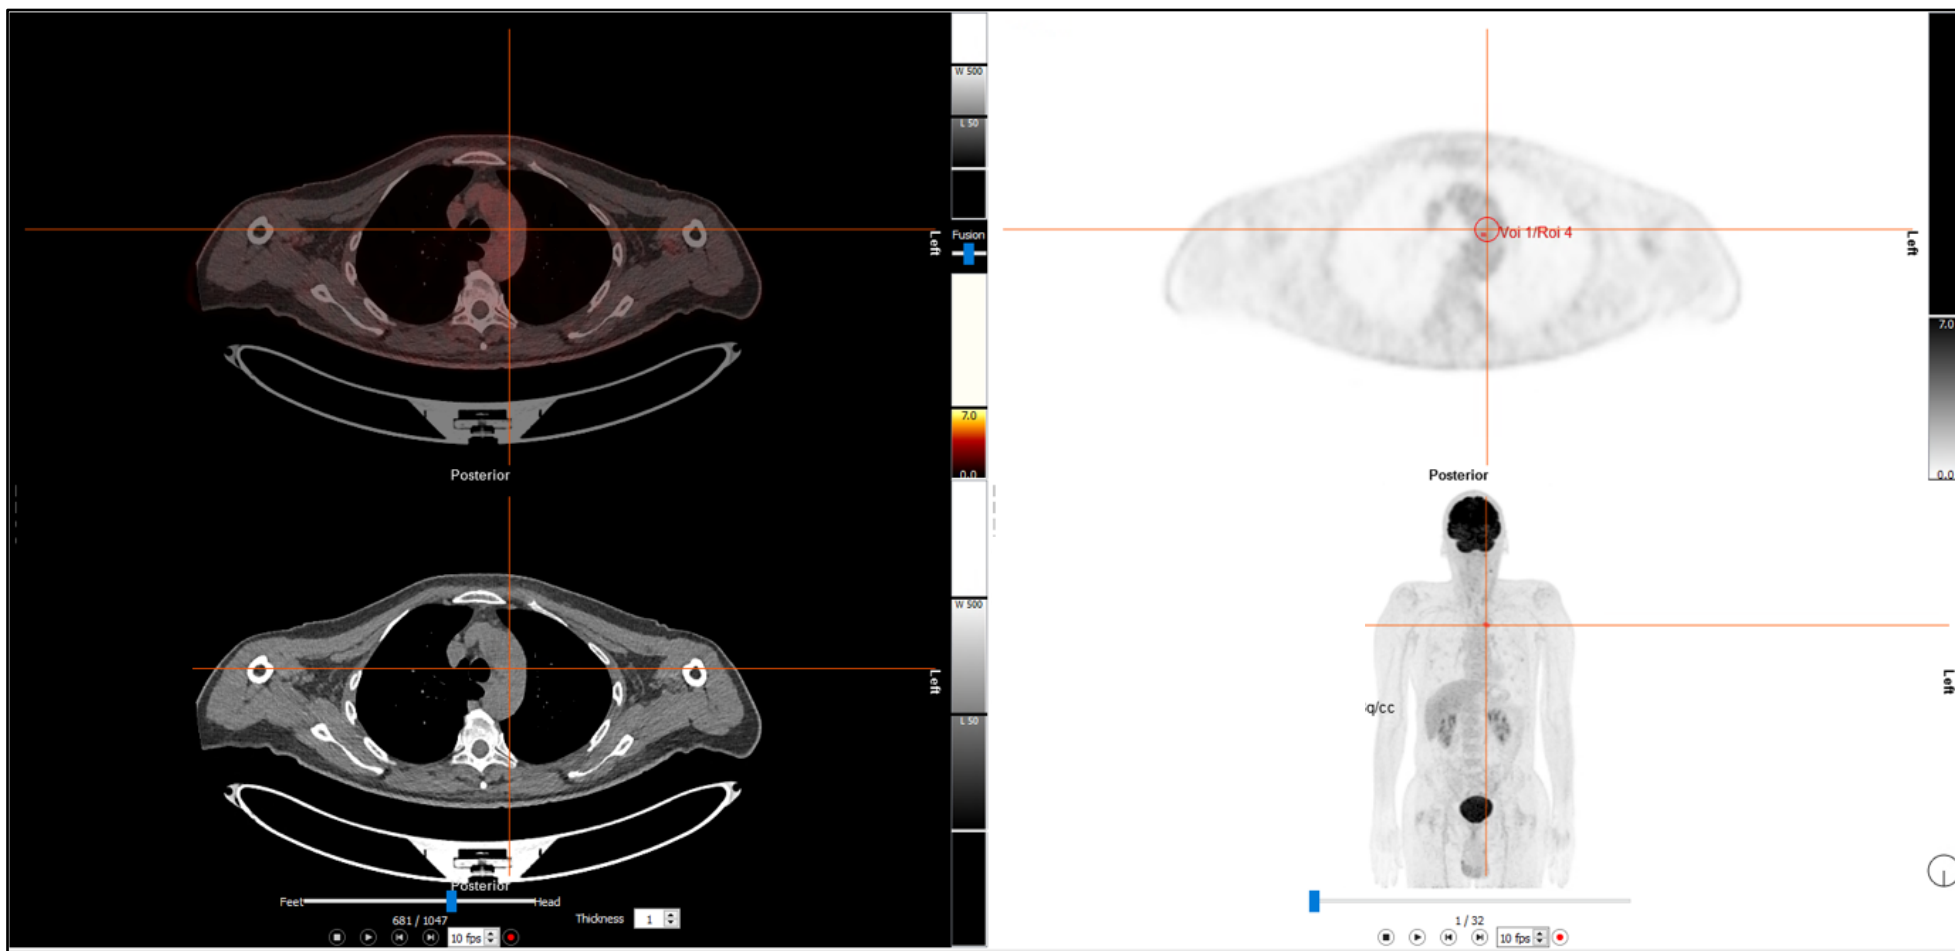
The blood pool  $SUV_{mean}$  and  $SUV_{max}$  derived from a VOI drawn over the aortic arch.
